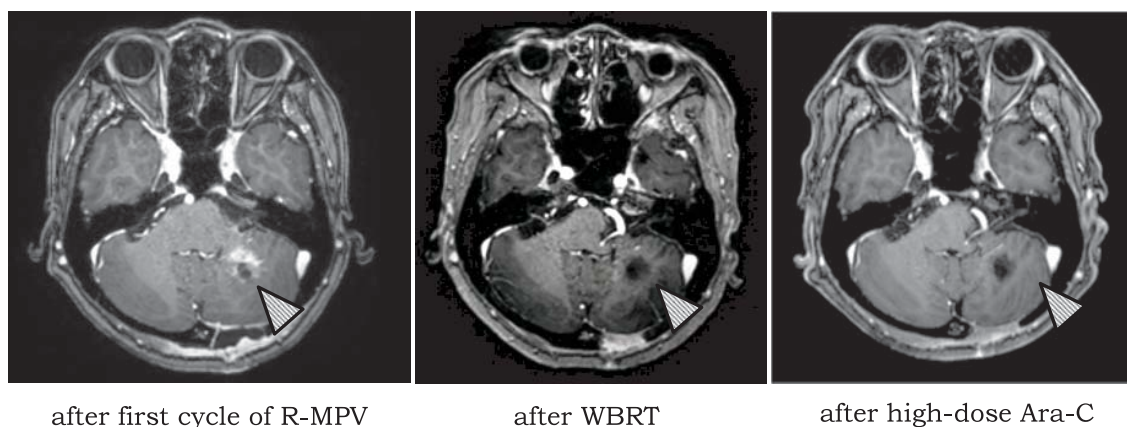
Response evaluation with brain magnetic resonance imaging (MRI). MRI scans after the first cycle of treatment revealed decreases in tumor volume and midline shift (*left panel*). After the completion of all treatments (*middle panel*: after whole-brain radiation therapy; *right panel*: after cytarabine), the contrast-enhanced area had completely disappeared and complete remission was achieved. R-MPV, rituximab, methotrexate, procarbazine, and vincristine; WBRT, whole-brain radiation therapy; Ara-C, cytarabine
